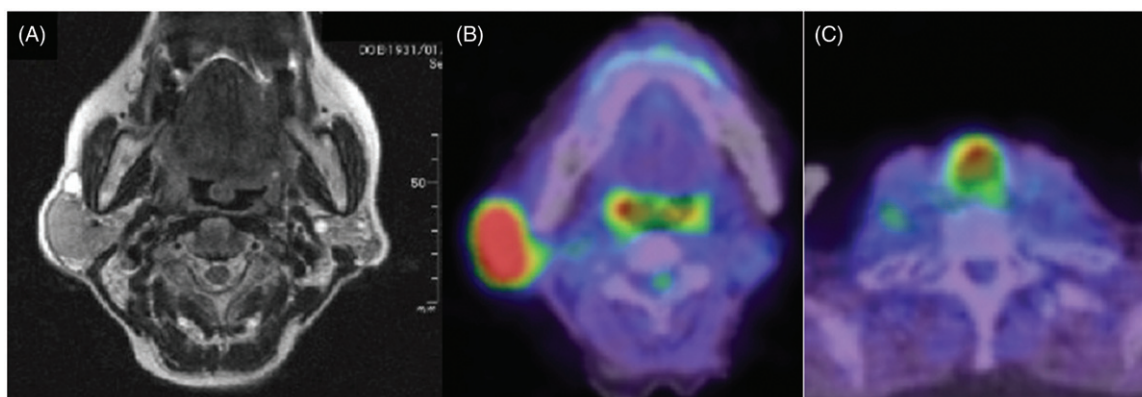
Magnetic resonance imaging showed a round mass in the right parotid gland. Both sides of the parotid gland accompanied with multiple small foci of high signal intensity area on T2-weighted image ((A) axial image) 18FDG-PET showed an abnormal uptake in right parotid gland (B) and subglottic space (C).
